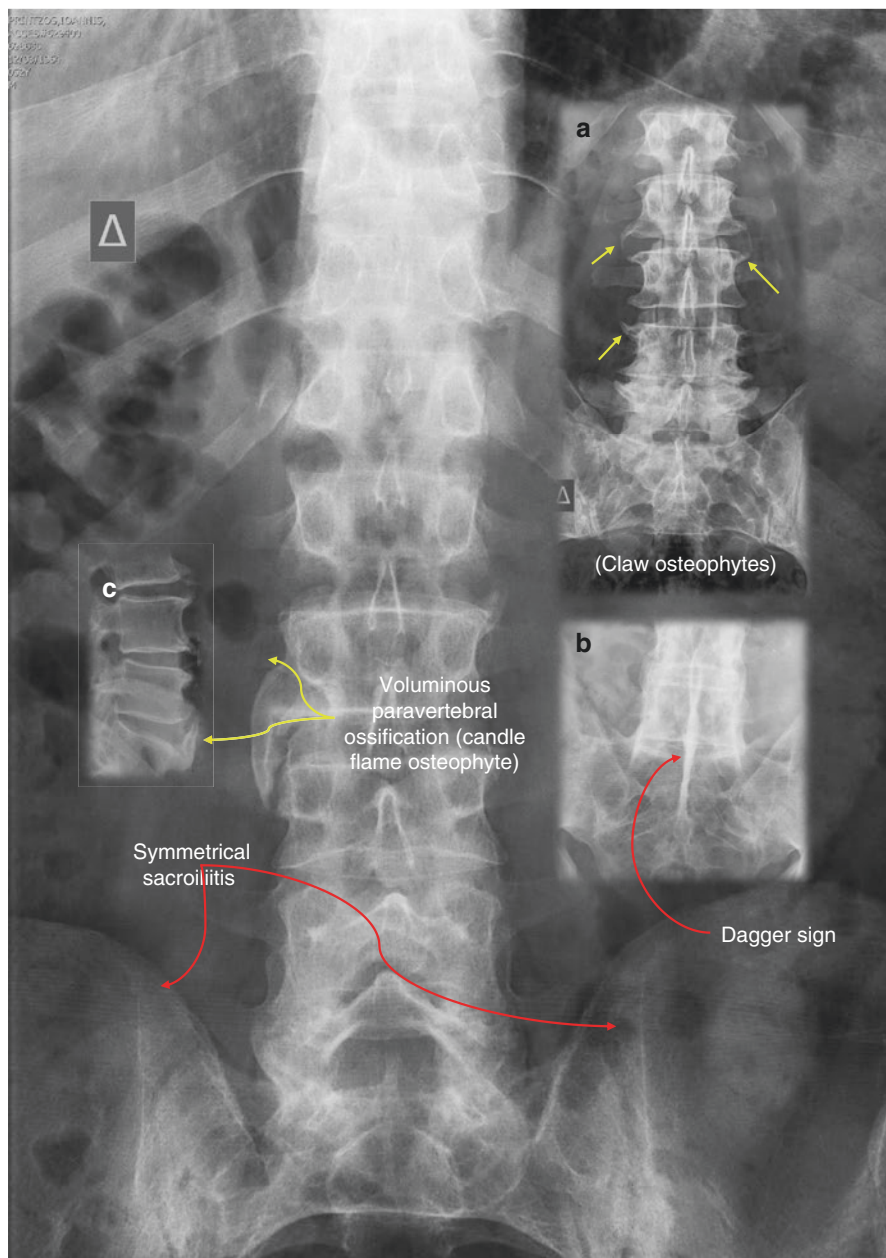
Radiographic findings – lumbar spine
